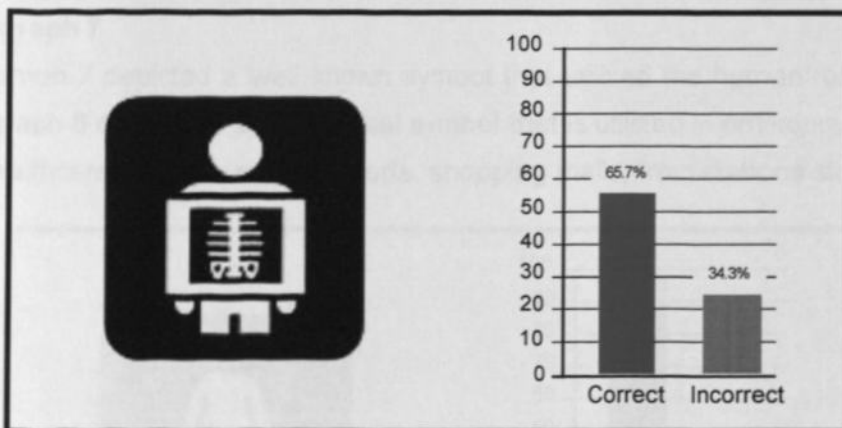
Recognition rate of X-Ray pictograph
